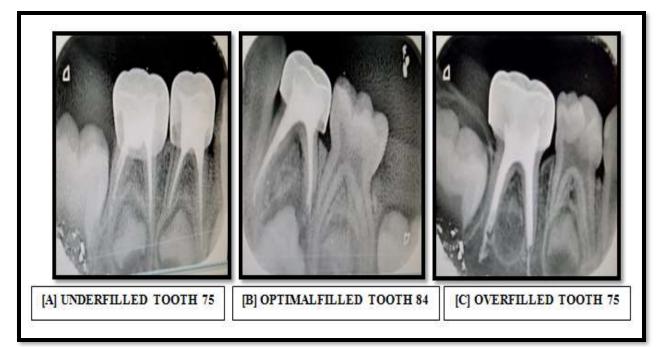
Immediate post-operative IOPA radiograph depicting different levels of quality of obturation according to Coll and Sadrian criteria (1996). [A] Underfilling [B] Optimal filling [C] Overfilling
